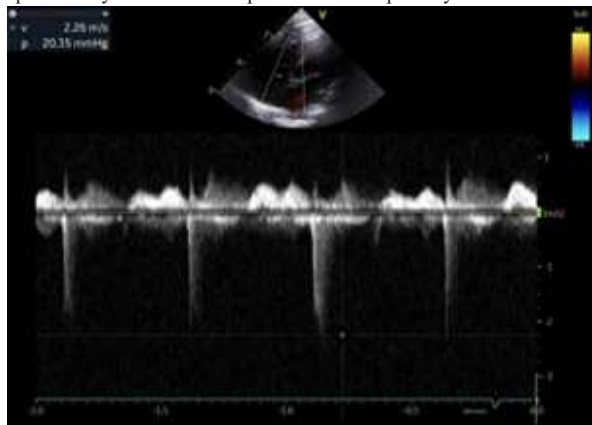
Apical four chamber view with colour doppler across the tricuspid regurgitation showing right ventricular systolic pressure of 20 mm Hg + right atrial pressure
